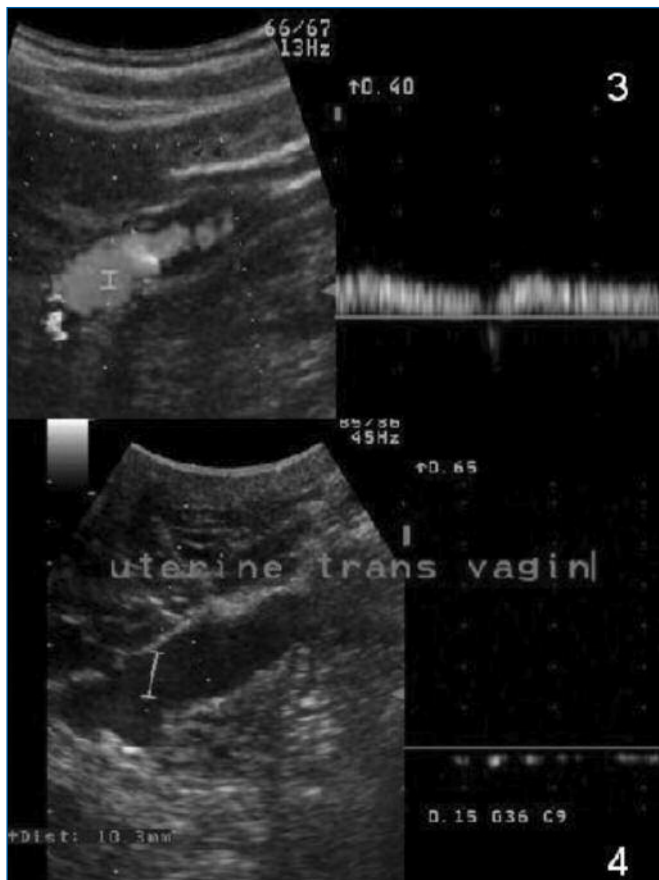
Transvaginal Doppler ultrasound. Upper: spontaneous incontinence of the ovarian vein / Lower: uterine varicosities, trans-cavitary pathway.
